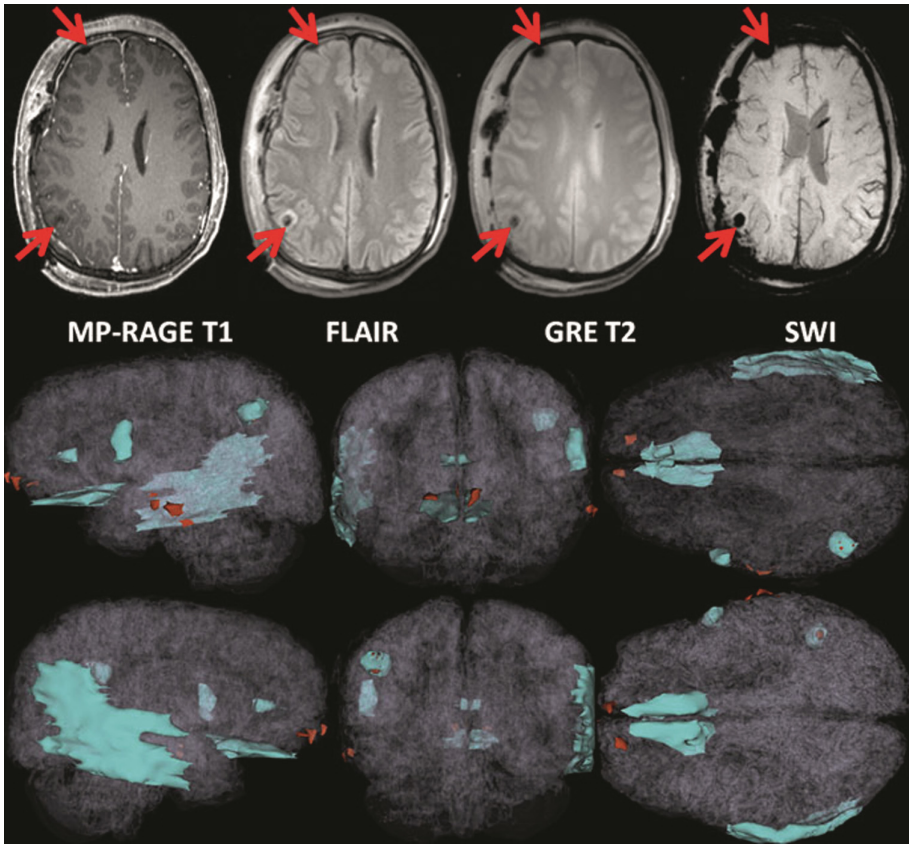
(A) Sample MRI slices acquired from a typical TBI patient using various sequences. Arrows indicate the locations of primary injuries. (B) Translucent models of the WM and GM (as reconstructed based on the segmentation) with edema (cyan) and hemorrhage (red) shown using opaque 3D models. Note the fronto-temporal spatial distribution of the injuries, typical in TBI (Color figure online).
